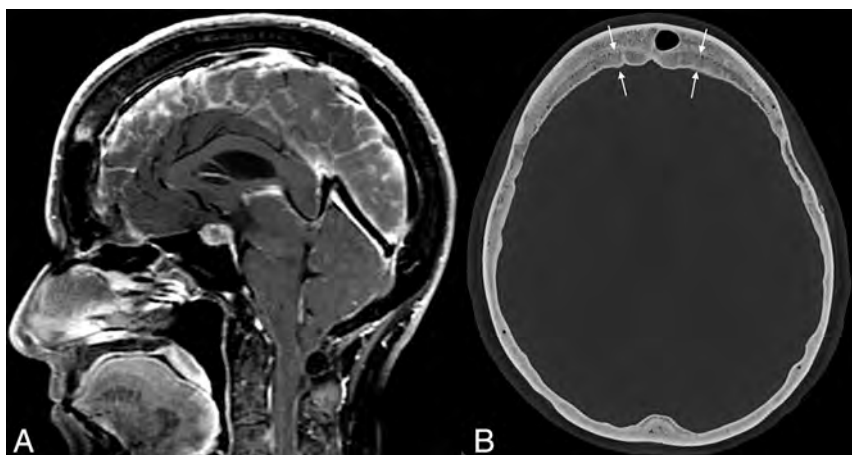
Example of layered calvarial thickening in a patient with SIH. Sagittal MR images (A) demonstrate classic findings of SIH, including pituitary enlargement, brain sag, and dural venous sinus engorgement. Axial CT image (B) in the same patient shows thickening of the bifrontal calvaria with characteristic layering related to preferential growth along the inner table of the skull (between straight arrows).
